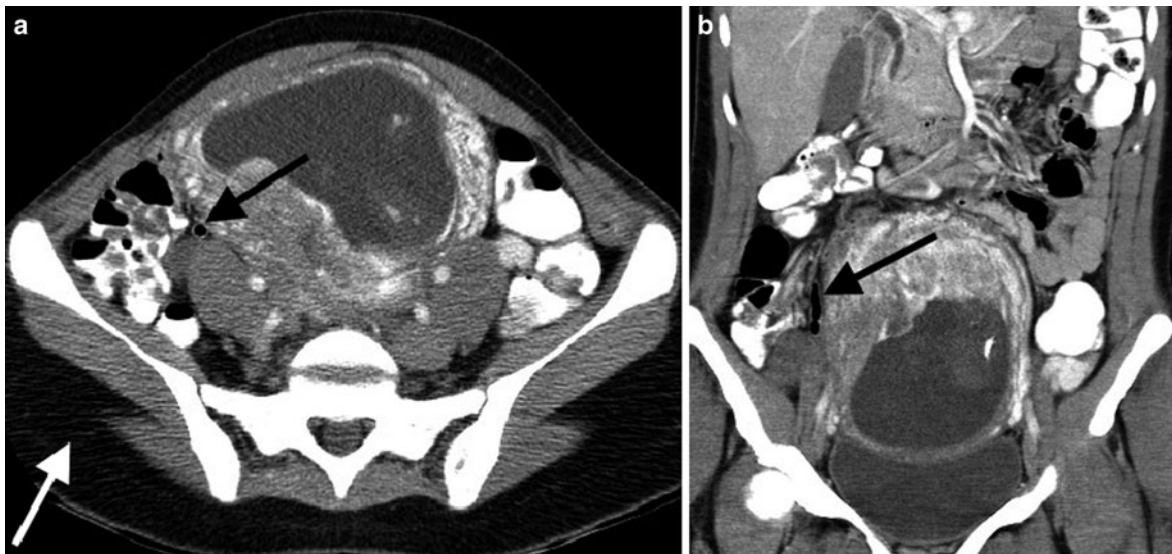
CT of 20-week pregnant patient with abdominal pain. a Axial CT image with intravenous and oral contrast shows a normal air-filled appendix (*black arrow*). The CT was performed without tube current modulation and a reduction of tube
